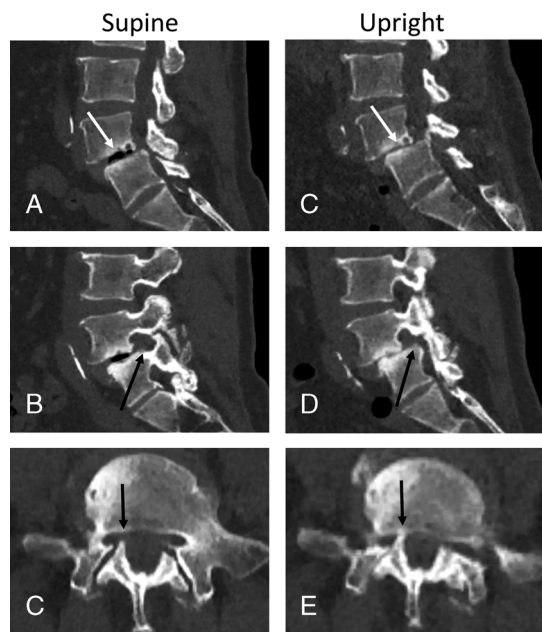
A case of spondylolisthesis. Supine CT showed spondylolisthesis between the L4 and L5 vertebrae in the reconstructed midsagittal image (A), and foraminal stenosis in the parasagittal image at the level of foramen (B) and the axial image (C). Upright CT showed a marked increase of stenosis in the spinal canal (D) and foramen (E and F).
